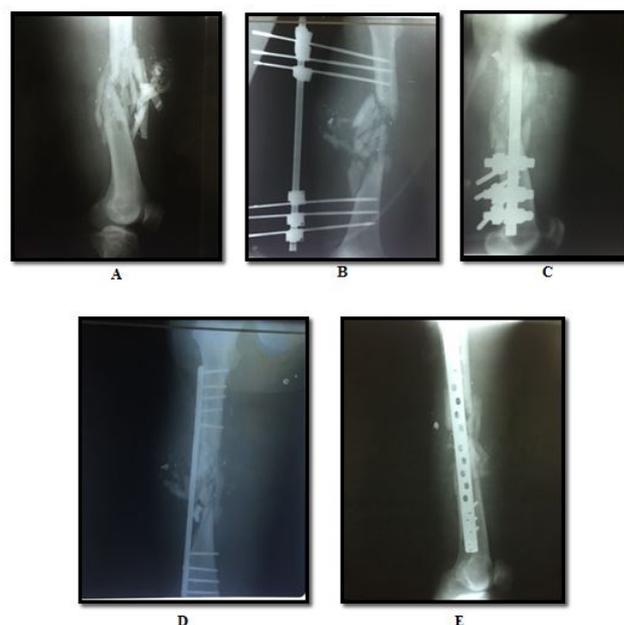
Patient number seven. (A) Type IIIA right side femoral shaft fracture caused by high velocity bullet. (B) AP plain radiograph of the fractured femur 24 h post injury. (C) Lateral radiograph 24 h post injury. (D) AP plain radiograph after 14 days. (E) Lateral radiograph after 14 days.
